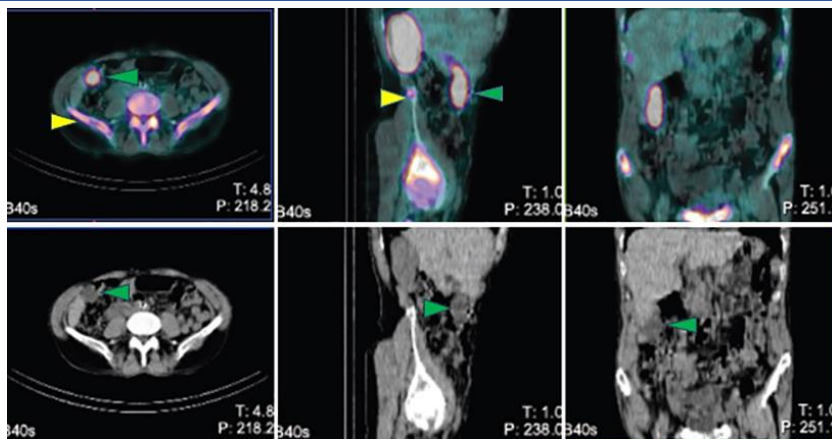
Fused SPECT/CT images revealed homogenous and diffuse accumulation within the dangle-shaped gallbladder (green arrow) extended to the pelvic cavity (yellow arrow)
